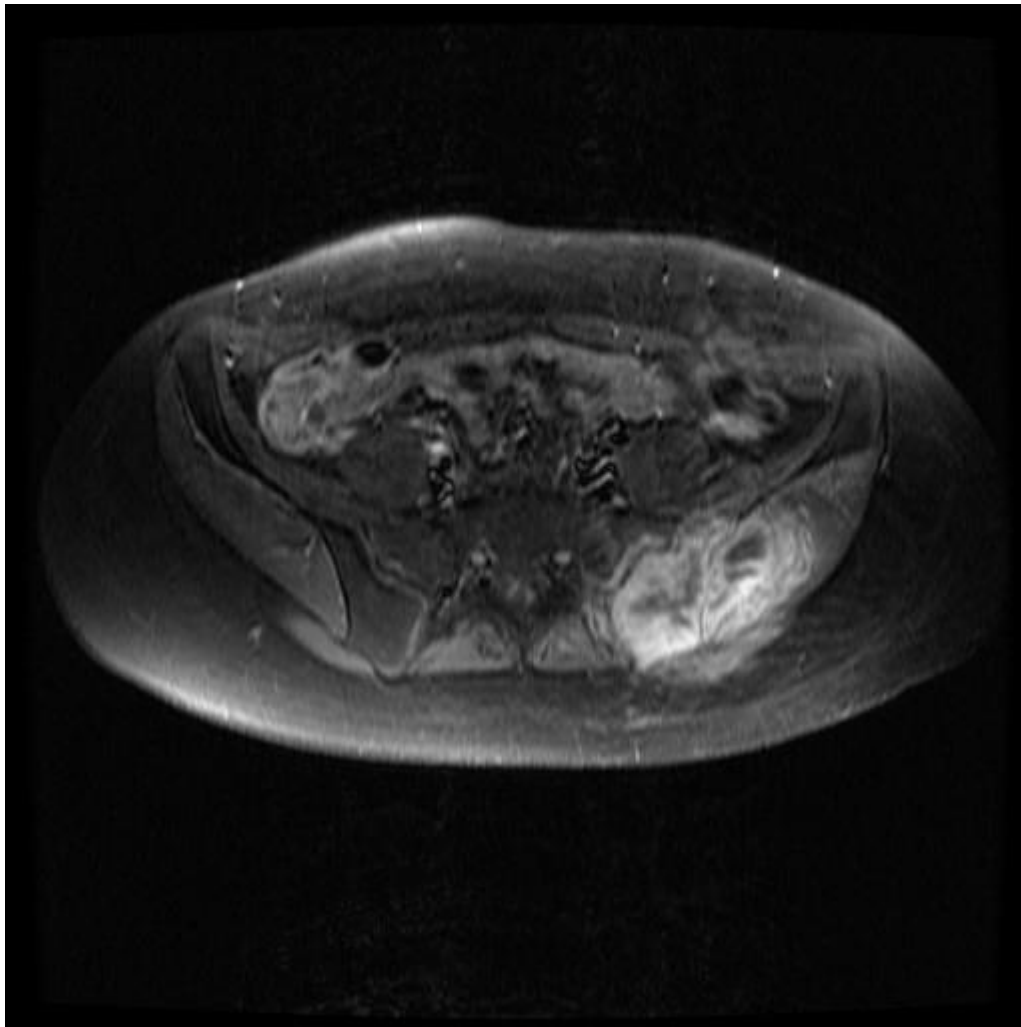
Axial view of a MRI scan of a pelvis showing a tumour affecting left ilium before chemotherapy treatment
